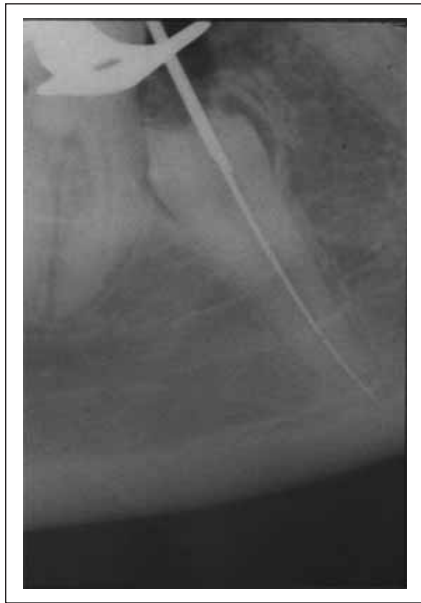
Guide file radiograph.
